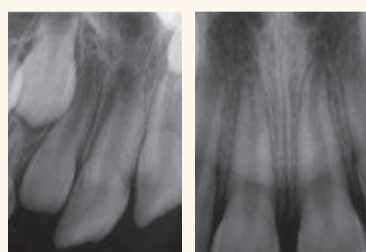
An immature tooth that was laterally luxated, as can be seen by the empty socket space around the apex on the radiograph.
